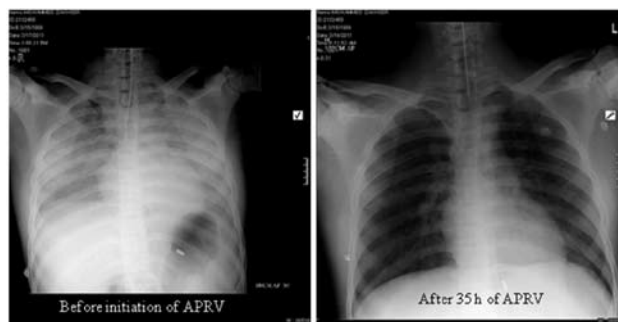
Chest X-ray before initiation of APRV (left) and 35 hours after initiation of APRV (right).
